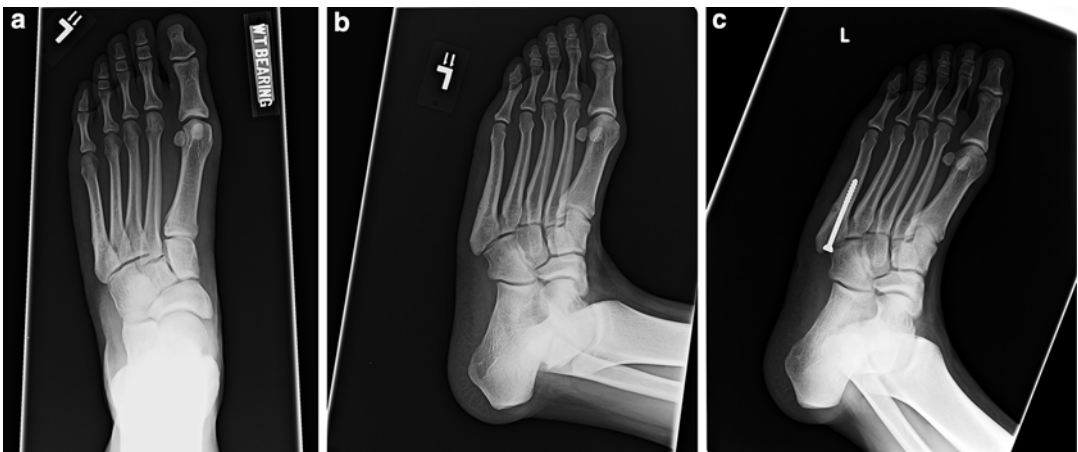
AP (a) and oblique (b) radiographs of the left foot demonstrating a stress fracture of the proximal fifth metatarsal. Oblique radiograph of the left foot after intramedullary screw fixation (c)
